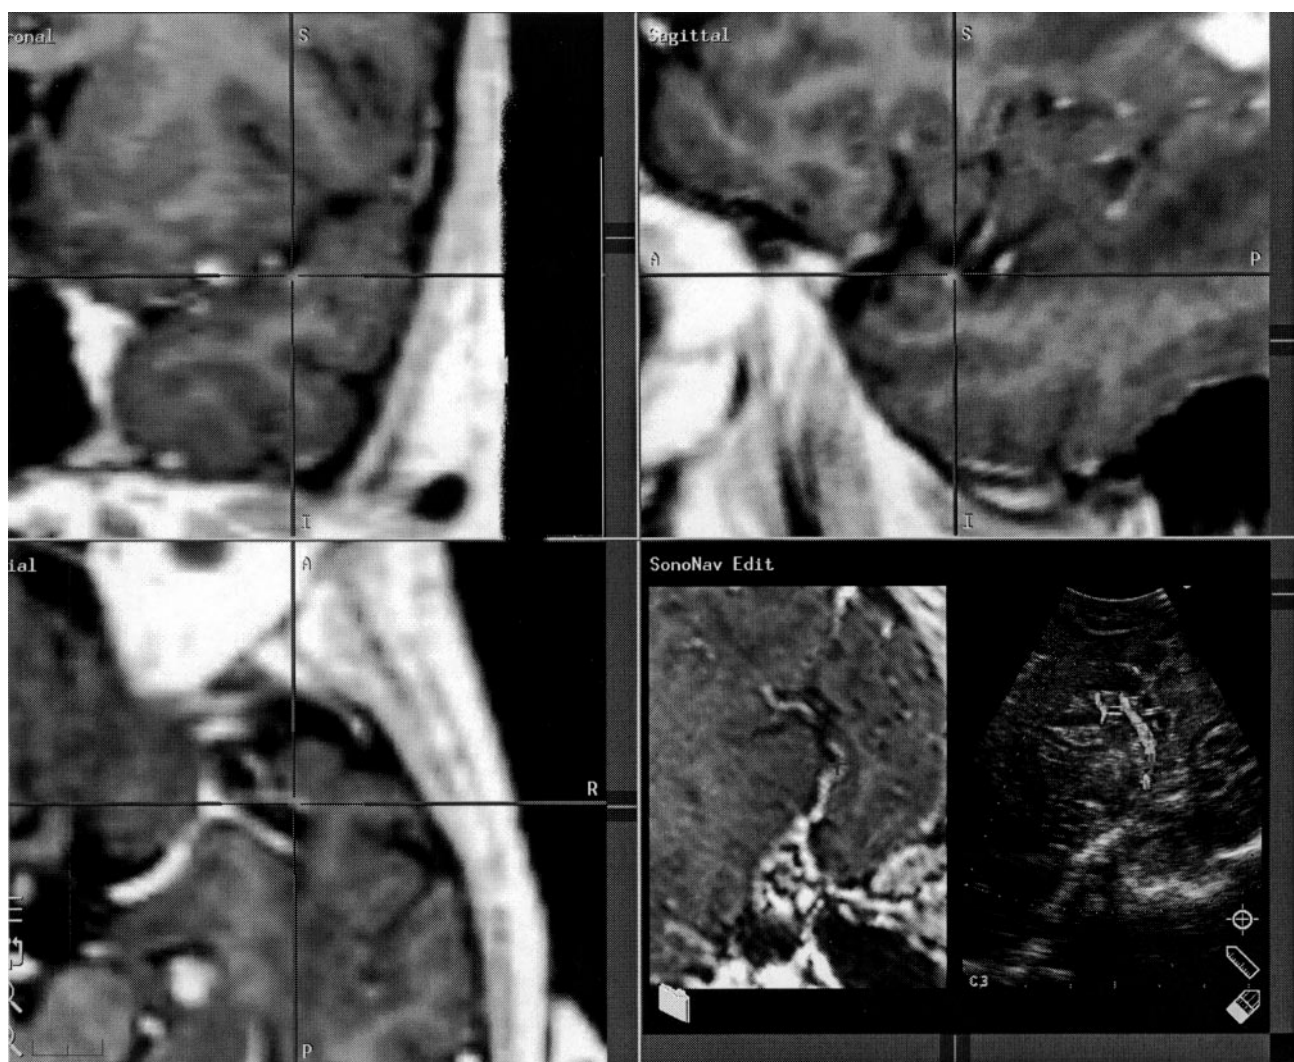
Screen shot from a StealthStation connected to an ultrasound device with a probe being tracked by an optical digitizer. The bottom right-hand window shows the real-time ultrasound display being fed into the navigational system (right) matched to a computer-generated reformat of the preoperative MRI images (left). A marker (red cross) has been placed on an object of interest seen in the ultrasound view (the M2 segment of the middle cerebral artery). The location of this spot is indicated not only on the reformatted MRI image, but also on the standard orthogonal views as seen in the other three windows, with the crosshairs of these windows indicating the position of the object of interest in the ultrasound display.
